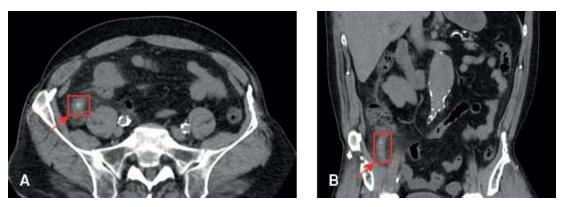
Axial (A) and coronal (B) computerized tomography (CT) images of patient with unperforated appendicitis. Acute appendicitis can be diagnosed on CT imaging by the presence of thickened appendiceal wall, fecalith, and/or periappendiceal fat stranding.
